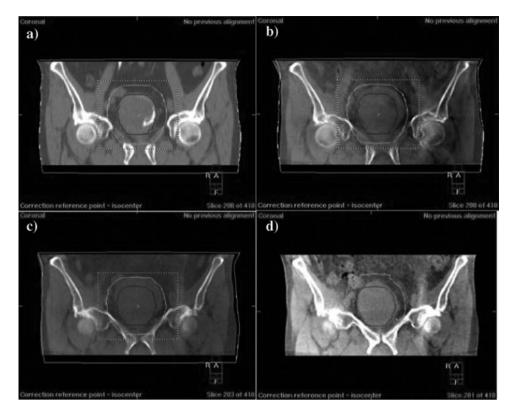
Coronal images of the bladder CTV and PTV. Figure (a) CT planning scan with the bladder outline representing the CTV with a 15mm expansion to create the PTV. (b) Day 1 CBCT. The bladder volume had increased and subsequently the PTV coverage of the bladder was compromised. (c) Day 2 CBCT confirmed a systematic increase in bladder volume and the PTV required enlargement. (d) Offline plan adaptation was performed and an anisotropic PTV margin applied. Whilst the lateral and caudal margins remained unchanged, the cranial margin was increased by 5mm to 20mm, subsequently ensuring adequate target volume coverage.
